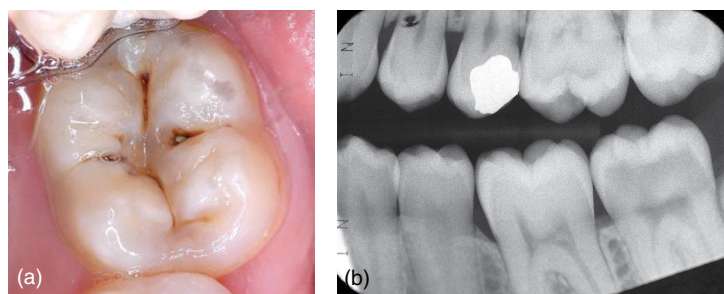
(a) Second molar with large, cavitated, occlusal lesion. (b) Radiograph of this tooth showing large lesion in dentine. This tooth is symptomless and vital.
